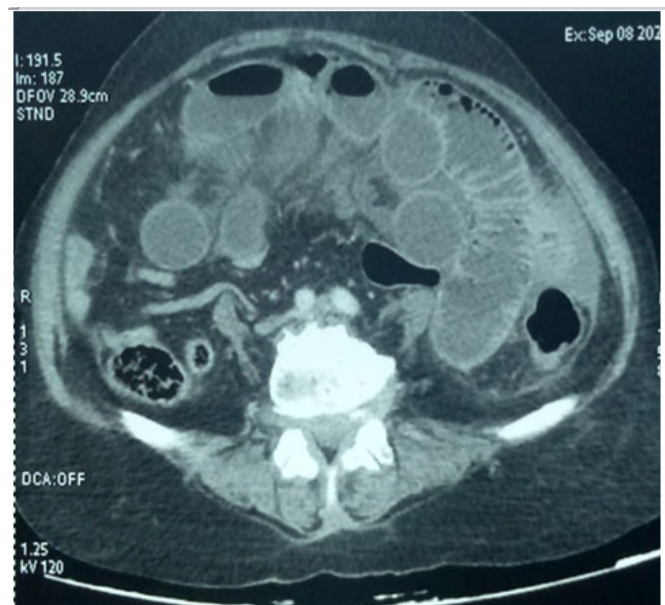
Abdominal CT scan showing small bowel distension upstream of a bird's beak aspect in the right flank.
